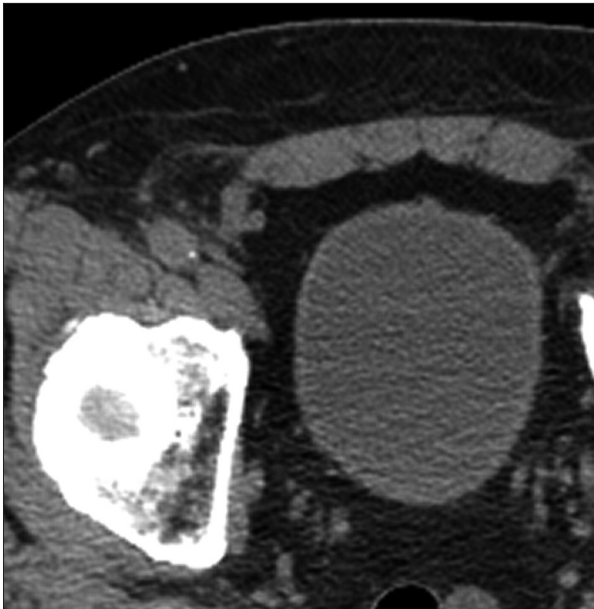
Amyand hernia. CT image shows the appendix within an Amyand's hernia. The indirect hernia originates superolateral to the course of the inferior epigastric artery. Reproduced from Burkhardt et al. [13] with permission from Radiographics. Copyright 2011.
